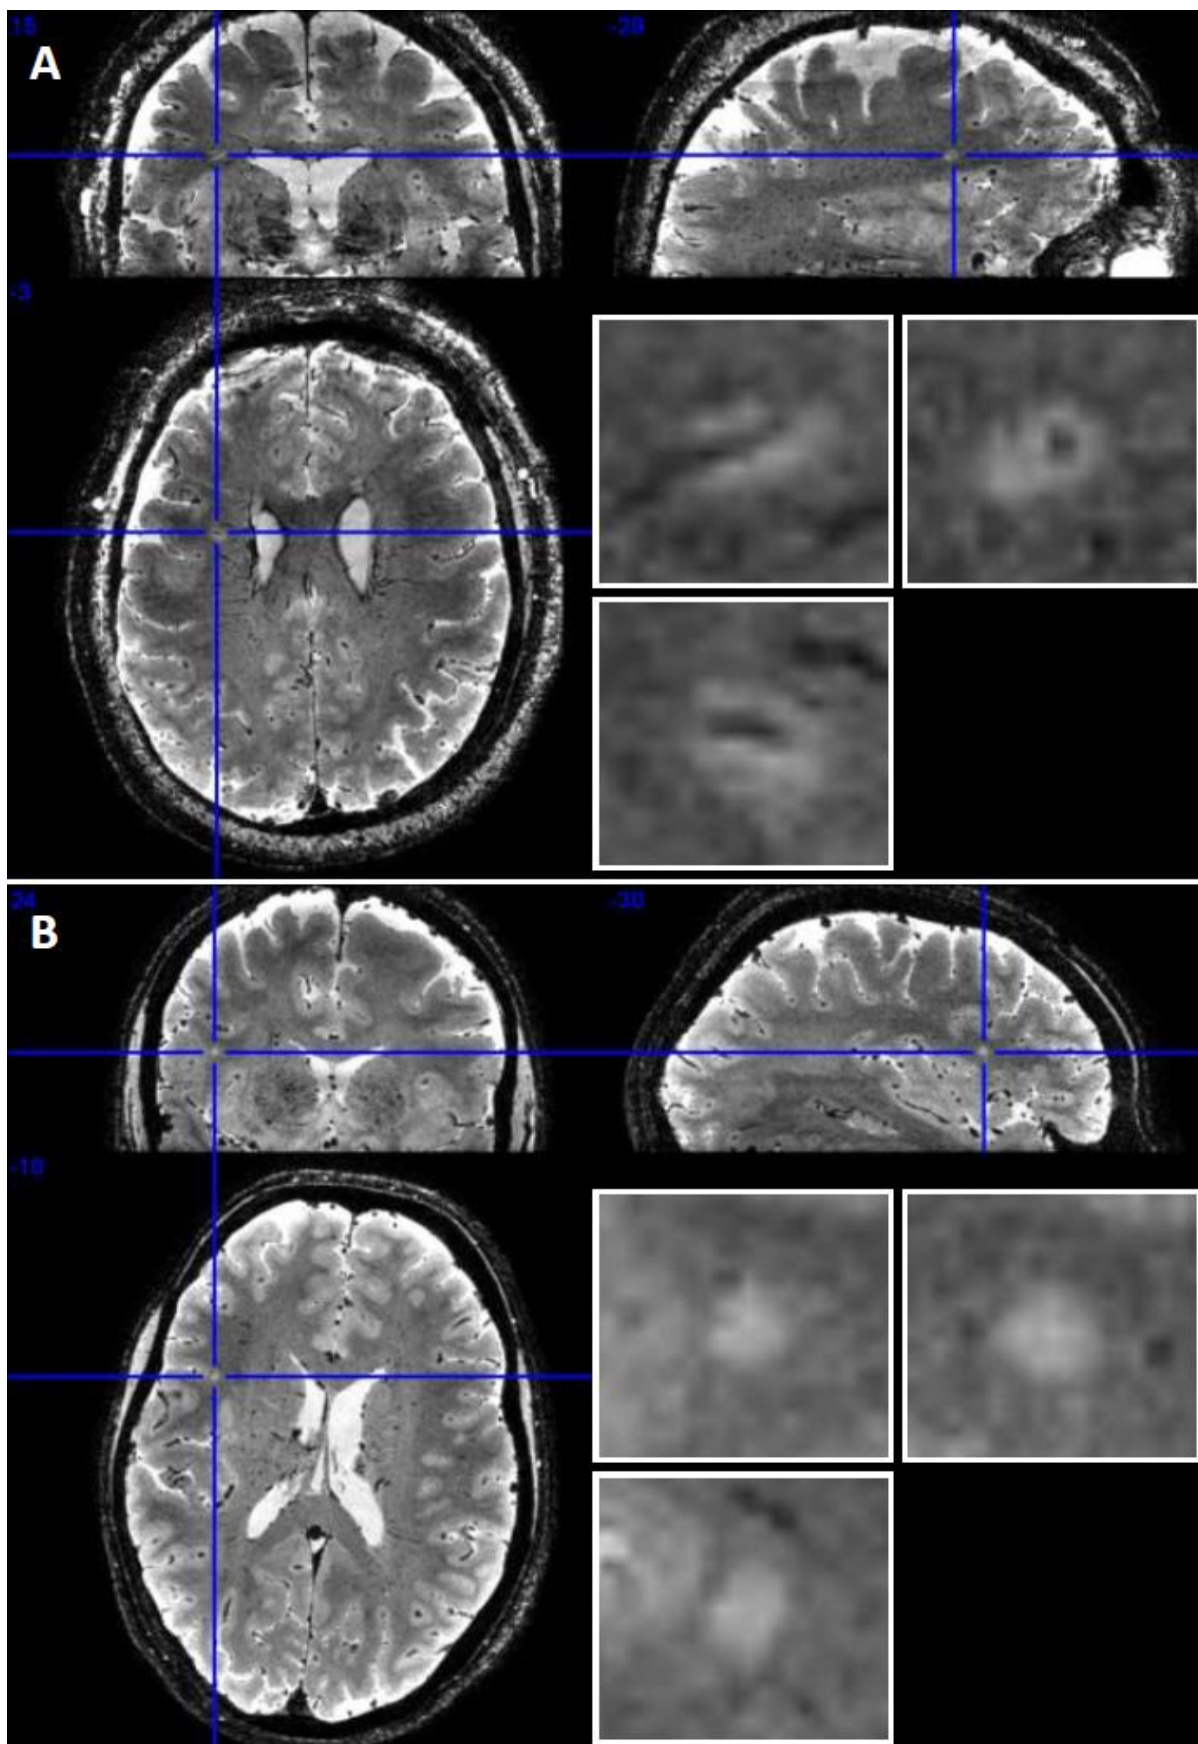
Characteristic 7T MRI MS lesion morphologies
